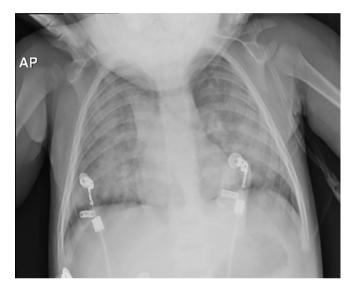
Chest X-ray at hospitalization (a few hours after the injury), in which pulmonary hypoexpansion with signs of alveolar-interstitial involvement suggestive of consolidations and pulmonary edema (i.e., acute respiratory distress syndrome) is observed.
